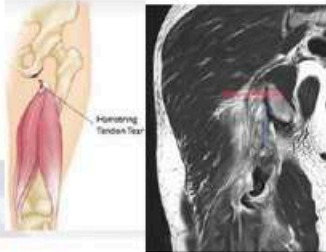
and 2 shows anatomical site of avulsion and MRI of patient with hamstring avulsion retracted 4cm.
